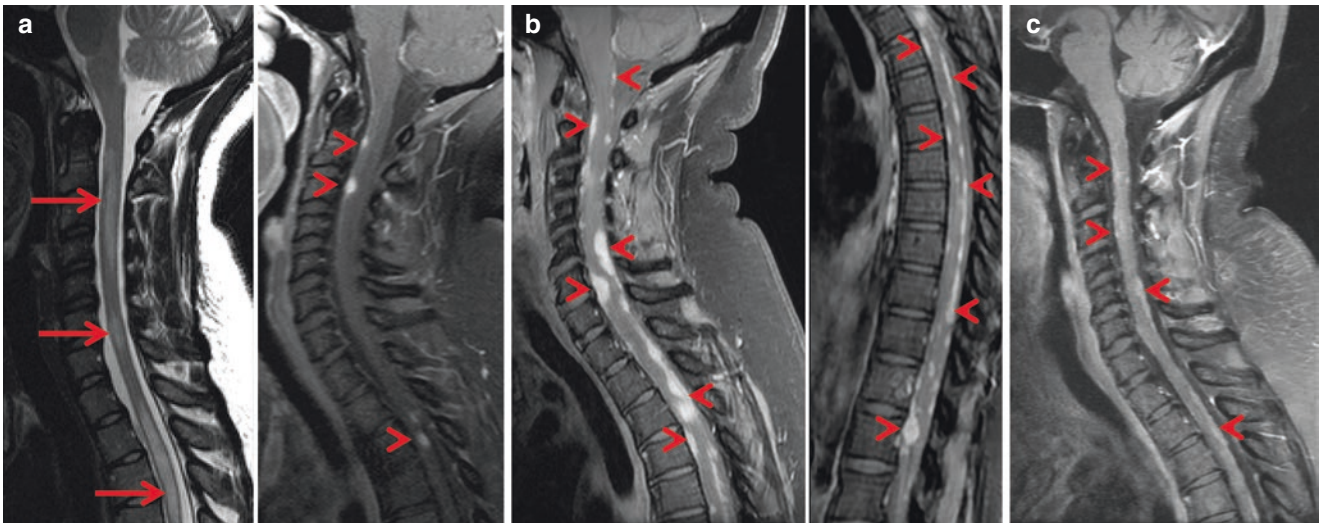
A 32-year-old African American woman developed left optic neuritis (magnetic resonance image not shown) with lower extremity hyper-reflexia. (a) Sagittal cervical spine magnetic resonance imaging (MRI)/short tau inversion recovery (STIR) demonstrated longitudinally extensive multifocal intramedullary T2 hyperintense lesions (left image, arrows) extending into the thoracic spinal cord. T1 postcontrast images (right) revealed several nodular spinal meningeal enhancing lesions (arrowheads). Cerebrospinal fluid (CSF) contained 88 nucleated cells/ μL (94% lymphocytes), protein 60, glucose 63, immunoglobulin G (IgG) index 1.18, oligoclonal bands in CSF only. Antinuclear antibodies (ANA) test was positive at >1:160 with a homogeneous pattern, and other rheumatologic antibodies were negative including serum aquaporin 4. Serum and CSF angiotensin-converting enzyme (ACE) levels were
